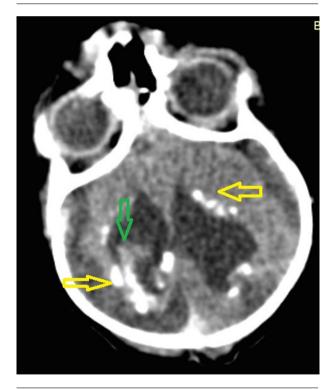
Cranial CT Demonstrated Dilatation of 3rd and Lateral Ventricles, Right Grade 1 Intraventricular Hemorrhage (Green Arrow) and Calcifications at Periventricular Areas (yellow Arrows).
